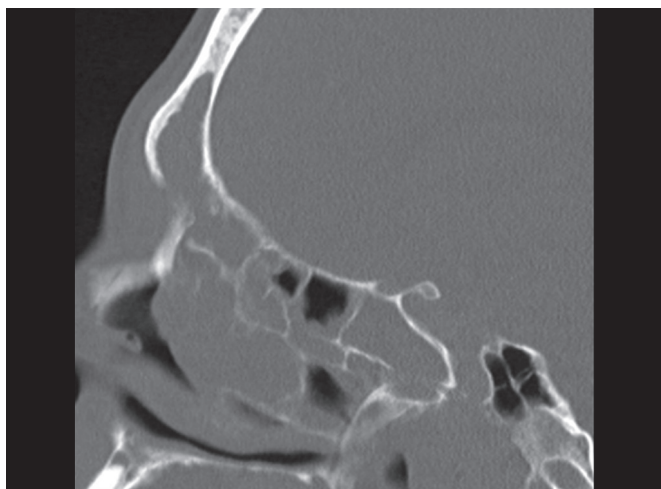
Sagittal computed tomography scan from a patient with acute rhinosinusitis and forehead swelling revealing dehiscence of the anterior table of the frontal sinus and opacification of the frontal, ethmoid, and sphenoid sinuses.
